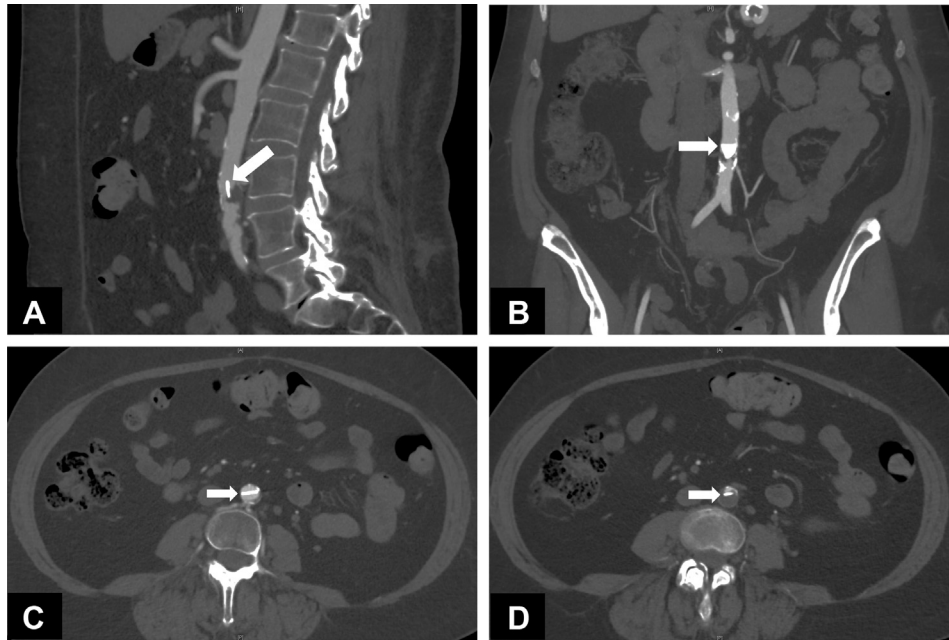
Abdominal and pelvic computed tomography (CT) scan showing a triangular platelike radiodensity measuring $10.5 \times 10.5 \times 1.5$ mm (arrows) associated with intraluminal thrombus or soft plaque. A, Coronal view. B, Sagittal view. C and D, Transverse views.
